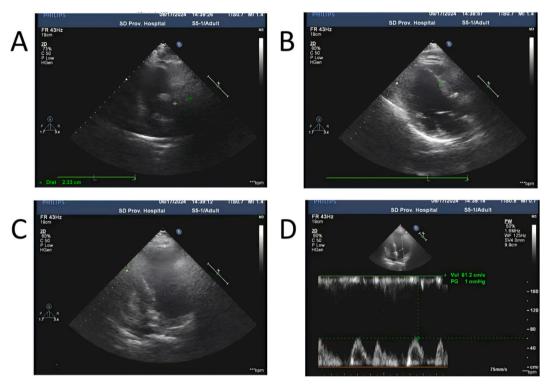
The echocardiographic imaging data before the repeat PCI shows old myocardial infarction in left ventricular anterior wall. The diameter of main pulmonary artery is 2.33 cm (A). The long axis view of the left heart shows severe akinesia in middle and lower segments of the ventricular septum, the anterior wall of the left ventricle, and the ventricular wall of the apical segment. The thickness of them become thinner slightly and the echo of them enhance (B). The short axis view of the heart base (C). Color doppler flow imaging (CDFI) shows a small amount of regurgitation signal across mitral valve (D).
